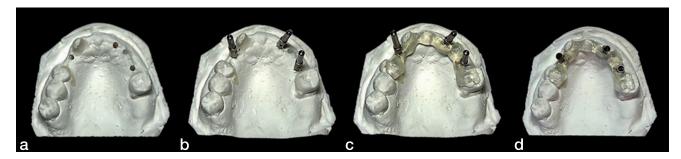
Fabrication of the diagnostic guide starts with drilling holes in the cast at ideal prosthetic positions: (a), guide posts and guide sleeves are placed into those holes; (b) light-cure resin is placed over the sleeves retentive element on the lingual and on the lingual and occlusal surfaces of adjacent teeth; (c) and the diagnostic guide is completed and ready for the CBCT scan intraorally (d).
